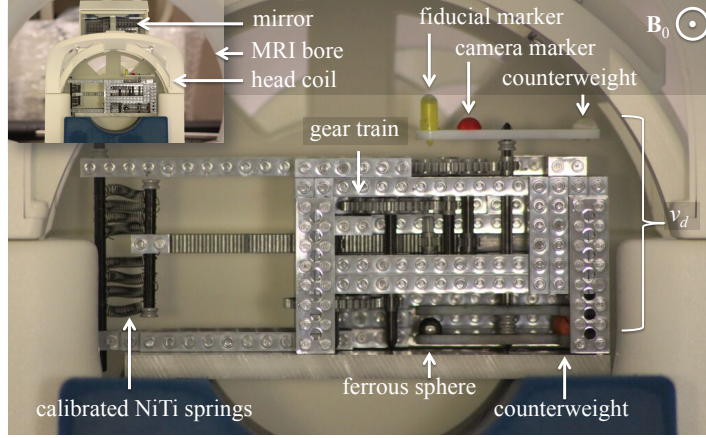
The prototype actuator used for single-rotor experiments, pictured inside the MRI scanner.
